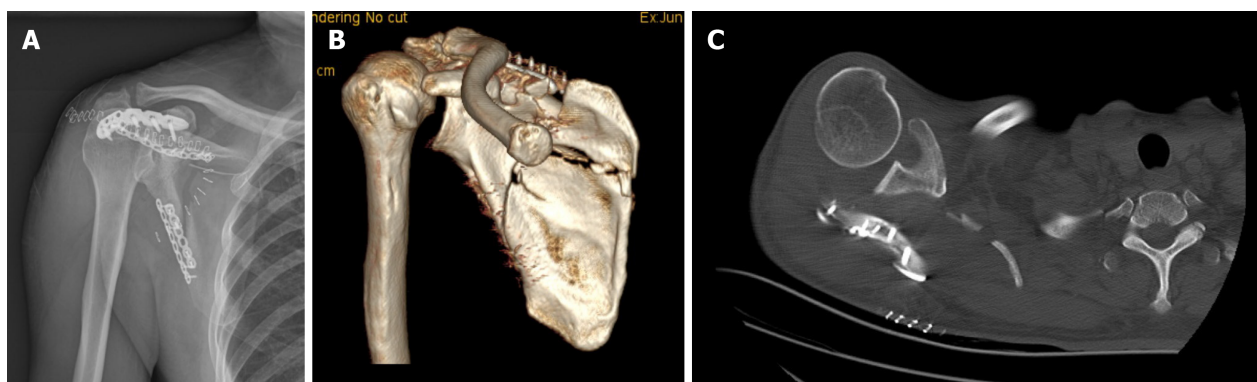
Dislocation of the glenohumeral joint after open reduction and internal fixation of the scapular neck fracture. A: Anterior-posterior X-ray; B: Three-dimensional reconstruction; C: Axial computed tomography image showing anatomical reduction of the scapula and glenohumeral joint dislocation.
